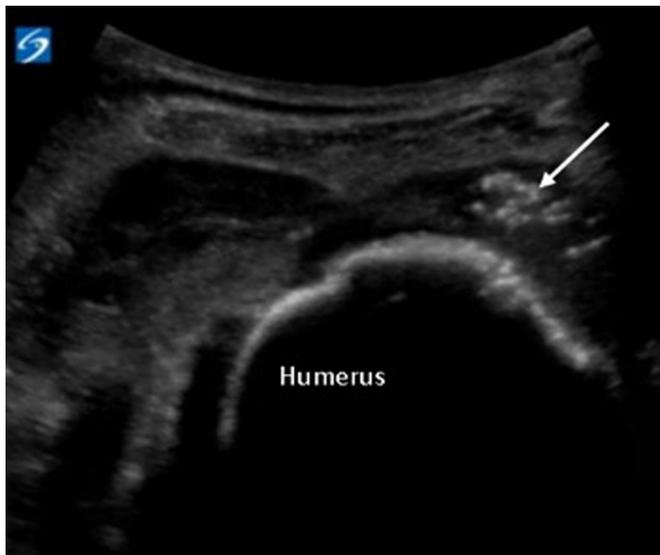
A transverse ultrasonographic image of the proximal humerus with periarticular fluid and gas (arrow).
